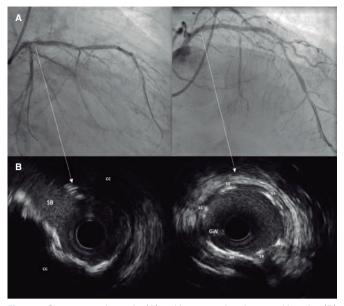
Coronary angiography (A) and intravascular ultrasound imaging (B) of ostial left anterior descending coronary artery showing severe concentric coronary calcification. Panels C, and D show the immediate outcomes after definitive stent implantation. CC, concentric calcification; GW, guidewire; SS, stent struts.
